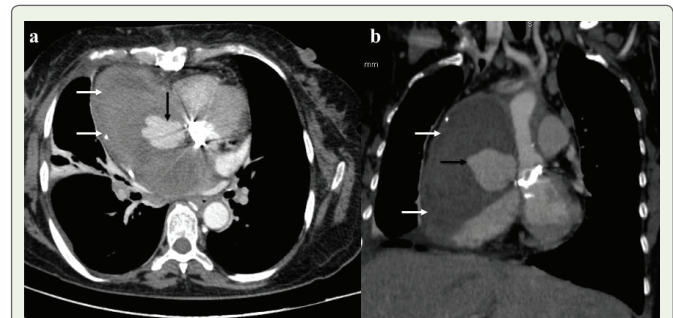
Axial and coronal contrast enhanced computed tomography (CECT) images showing well-defined pseudoaneurysm (black arrows) adjacent to the prosthetic aortic valve with surrounding large mediastinal hematoma (white arrows).
